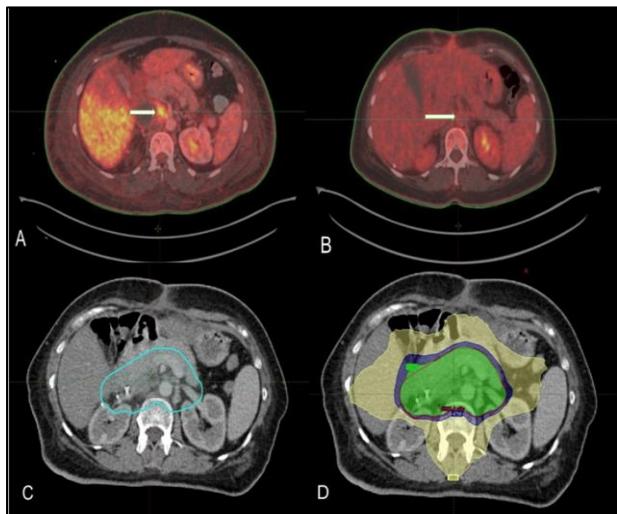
Axial views: A) pre-operative PET CT scan (white arrow showing FDG uptake), B) post-operative PET CT scan (absence of FDG uptake), C) treatment volume, D) dose distribution (yellow: 50% isodose of total dose, 3000cGy; blue: 95% isodose of total dose, 5700 cGy; green: 95% isodose of phase I, 4750cGy).
